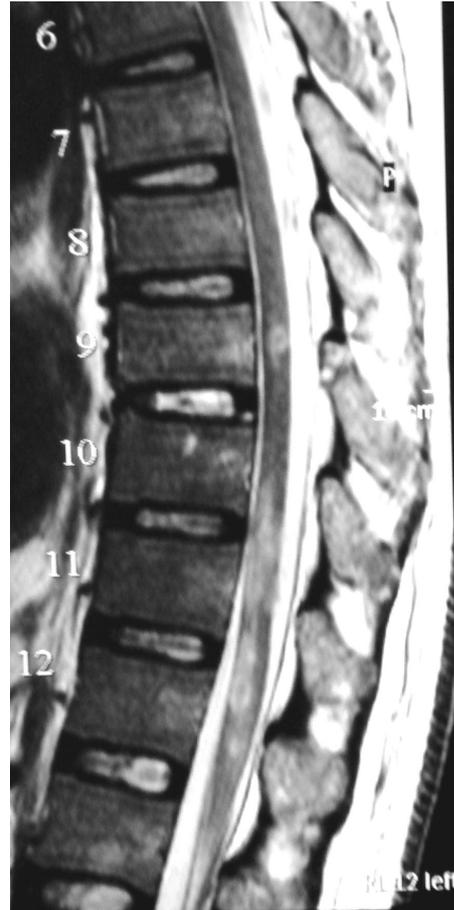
Magnetic resonance imaging, T2-weighted sagittal image of the thoracolumbar spine. High-intensity patchy area is seen in the cord between Thoracic10 and Thoracic12. Fracture lines on the spinous processes of T6 and T7 are also observed.
